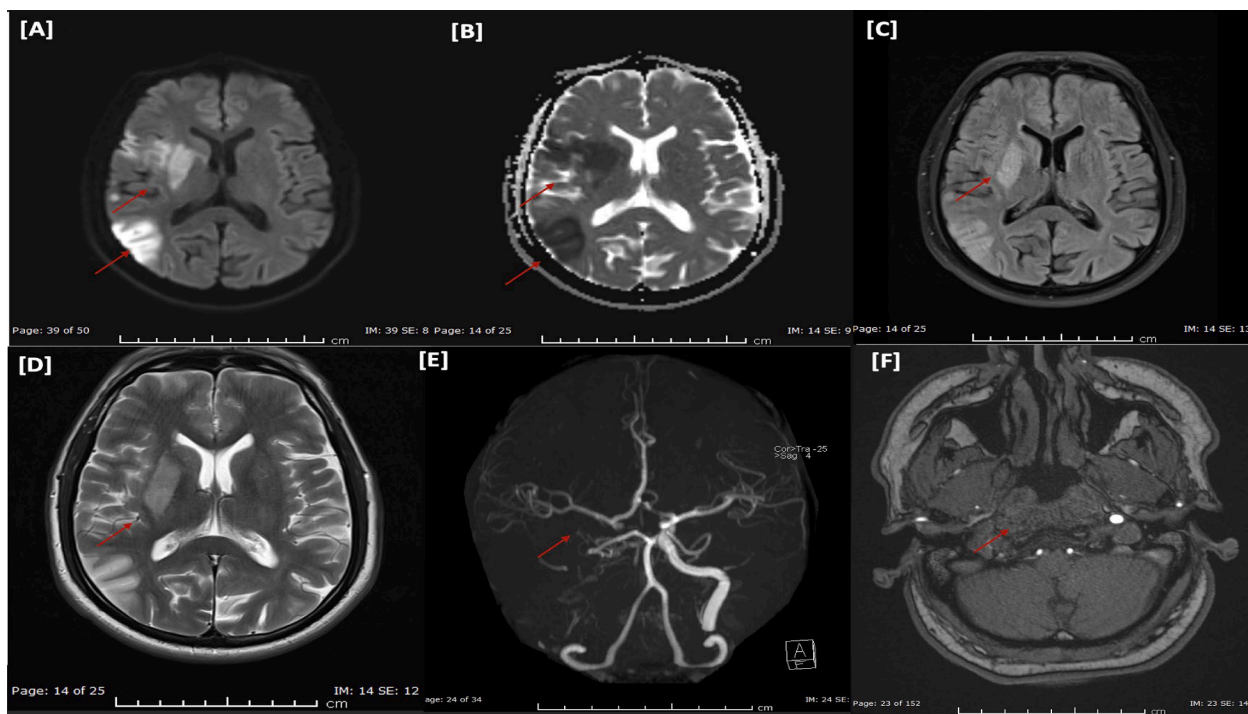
[A–E] MRI /MRA head – Case one with right ICA dissection and elongated styloid processes. [A and B] Axial DWI and ADC map images of the brain showing recent ischemic infarctions along the right MCA territory in the right temporal and parieto-occipital region involving the right lentiform nucleus. [C and D] Axial FLAIR and T2 WI showing corresponding hyperintensities. [E and F] 3D TOF MRA of the intracranial arteries showed absent flow in the intracranial course of the right ICA while preserved flow noted along the right ACA and MCA.
